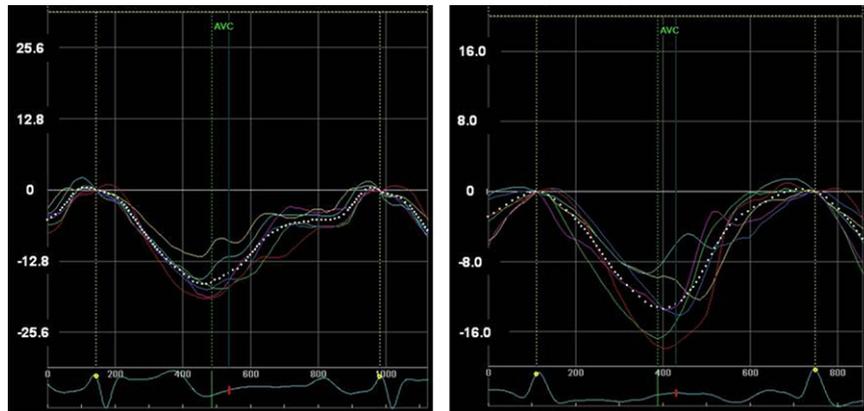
Segmental longitudinal strain measured by two-dimensional speckle-tracking echocardiography from an apical four-chamber view. The curves were obtained from a patient with severe AR before (*left*) and after (*right*) AVR. The global systolic strain is reduced before surgery compared with healthy individuals.
